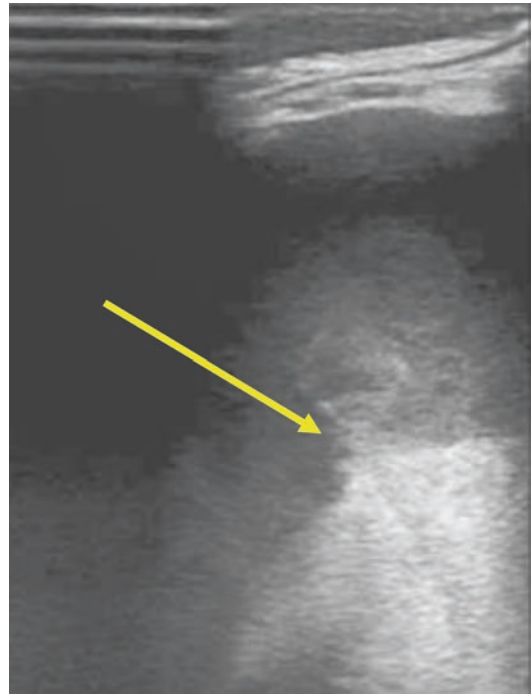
Hemothorax in a child on ECMO with acute hypotension. Ultrasound identified a location of pulsatile bleeding from the lung which was the source of the acute hemothorax and etiology of hemodynamic instability
